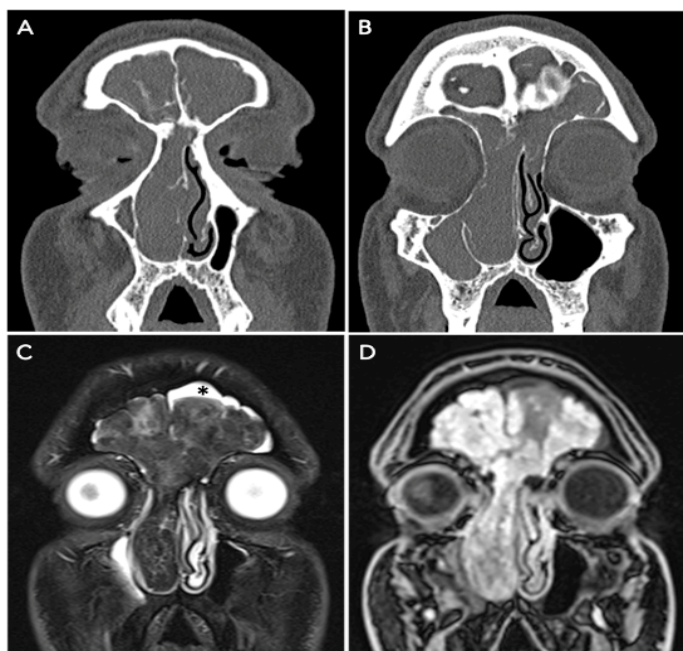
Preoperative imaging investigations showing a neof ormation involving the right ethmoid sinus, bilateral frontal sinuses and completely occupying the right nasal fossa. CT scan shows thinning of bony septa of right anterior ethmoidal complex as well as remodeling of interfrontal septum and frontal beak (A-B). At MRI, the lesion appears hypointense on coronal T2-weighted (C), retained secretions lie in the superior portion of left frontal sinus (asterisk). Post contrast spoiled 3D gradient echo T1-weighted fat saturated sequences show diffuse inhomogeneous enhancement (D), the mass is characterized by a "salt and pepper" appearance due to the presence of intralésional flow-voids (C).
